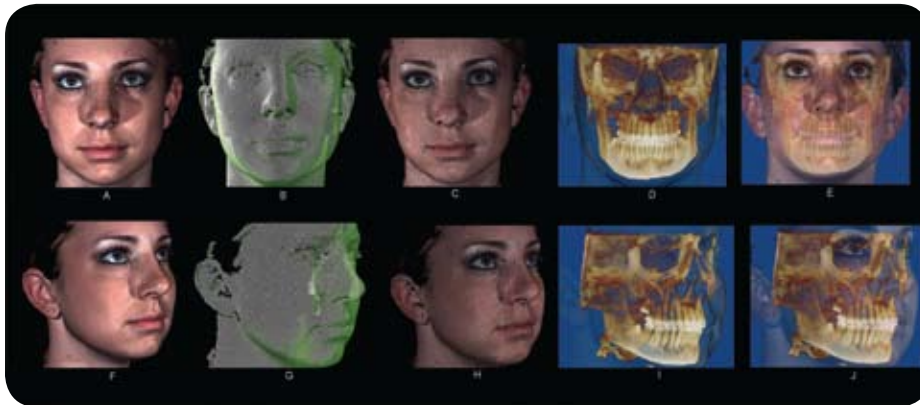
This figure shows a face image that was captured with 3dMDface using a range of 3-D visualization options. A and F show a photo-textured face from two points of view. B and G show the geometry of the face rendered as a polygon mesh. The stereophotogrammetry reconstruction algorithm creates a point cloud of approximately 100,000 surface locations. The polygon mesh was created from this point cloud using the points as vertices. C and H show the photo-textured polygon mesh using a volume render method of display. D and I show the polygon mesh of the face registered to the CBCT. The mesh and skeleton were registered using Dolphin 3-D software and displayed using a volume-rendering technique. E and J are a volume-rendering display created by Dolphin 3-D showing the 3dMD facial image registered to the CBCT generated by an Imaging Sciences (Hatfield, Penn.), iCAT machine.
